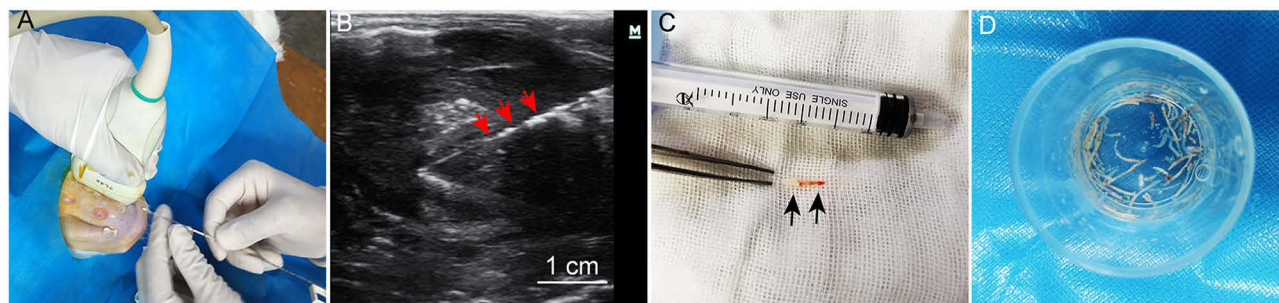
Harvesting and preparation of VX2 tumor tissue fragments. (A and B) Ultrasound-guided puncture of the VX2 tumor in the gluteal region of a tumor-bearing rabbit. The display screen shows the biopsy needle positioned within the tumor tissue (red arrows indicate the biopsy needle). (C) Intact tumor tissue fragments obtained by the biopsy needle (black arrows), approximately 1 cm in length, with minimal surface blood residue. (D) Tumor tissue fragments after removal of necrotic components, preserved in saline for subsequent use.
